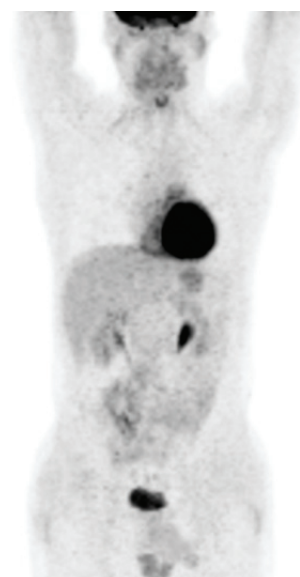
Positron emission tomography (PET)/computed tomography (CT) images demonstrating the normal biodistribution of 18F-fluorodeoxyglucose (FDG) in a patient in complete remission. There is avid FDG uptake in the brain, myocardium and urinary tract, with normal FDG uptake in salivary glands, liver, spleen and gastrointestinal tract.
